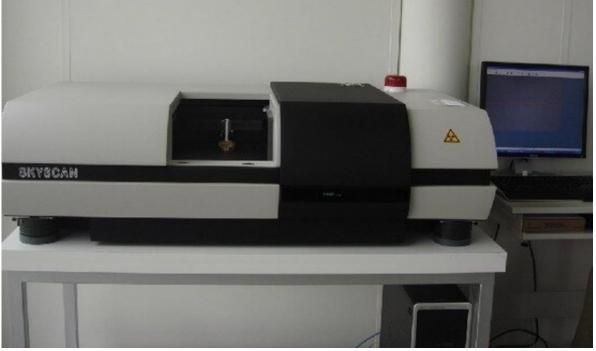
Micro CT scan, model Skyscan 1072, Skyscan, Aartselaar, Belgium
